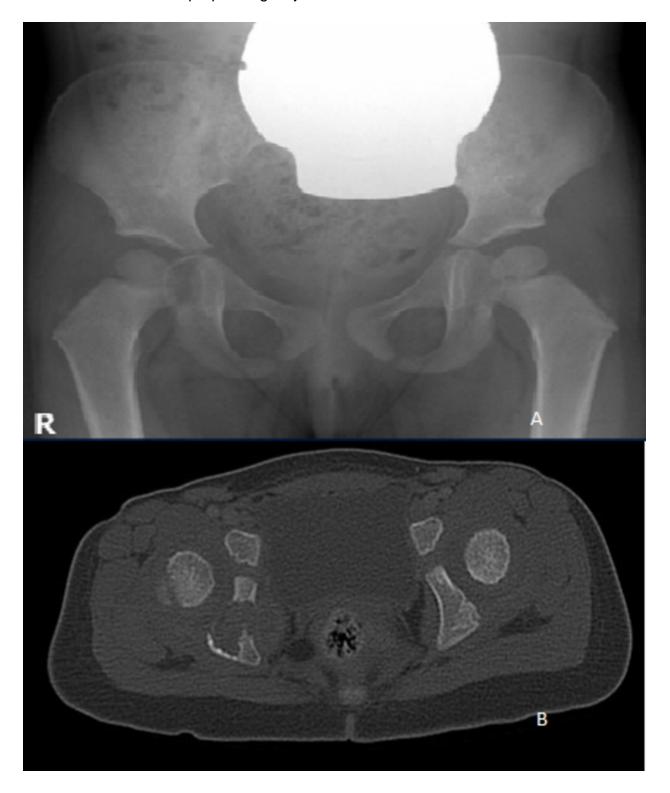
Eosinophilic granuloma. Frontal radiography (A) shows a large well-defined lytic lesion in the right pelvic bone. Axial computed tomography (B) of the same patient reveals a large lytic lesion located in the right pelvic bone with cortical disruption.
